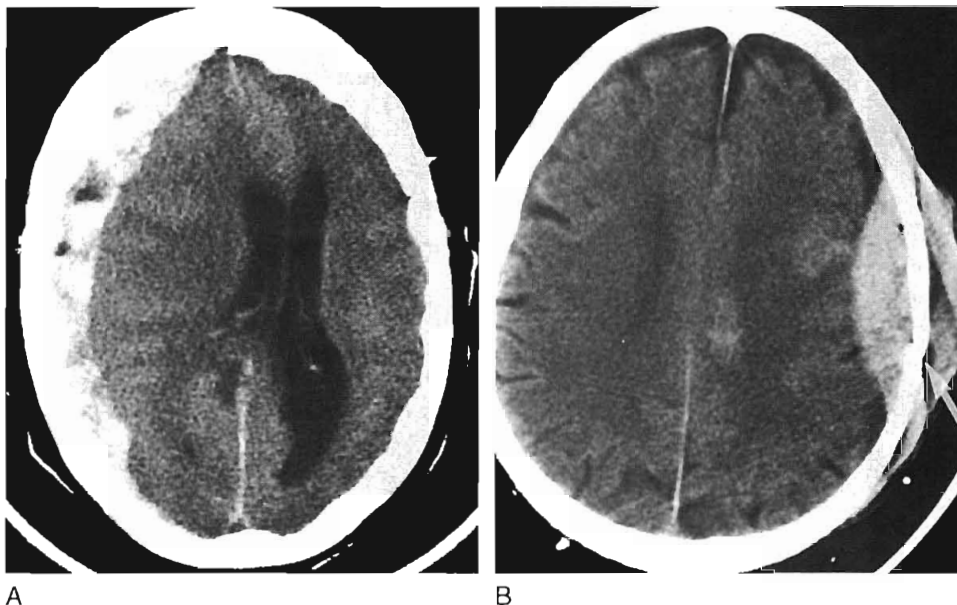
Subdural and epidural hematoma. *A*, Axial CT scan of the head demonstrates a mixed-density subdural hematoma along the right frontoparietal lobes. The mixed-density appearance is most likely due to the presence of unretracted, semiliquid clot. *B*, Axial CT scan of the head demonstrates a left biconvex hyperdense collection that is classic for epidural hematoma. A fracture (*arrow*) can also be identified.
